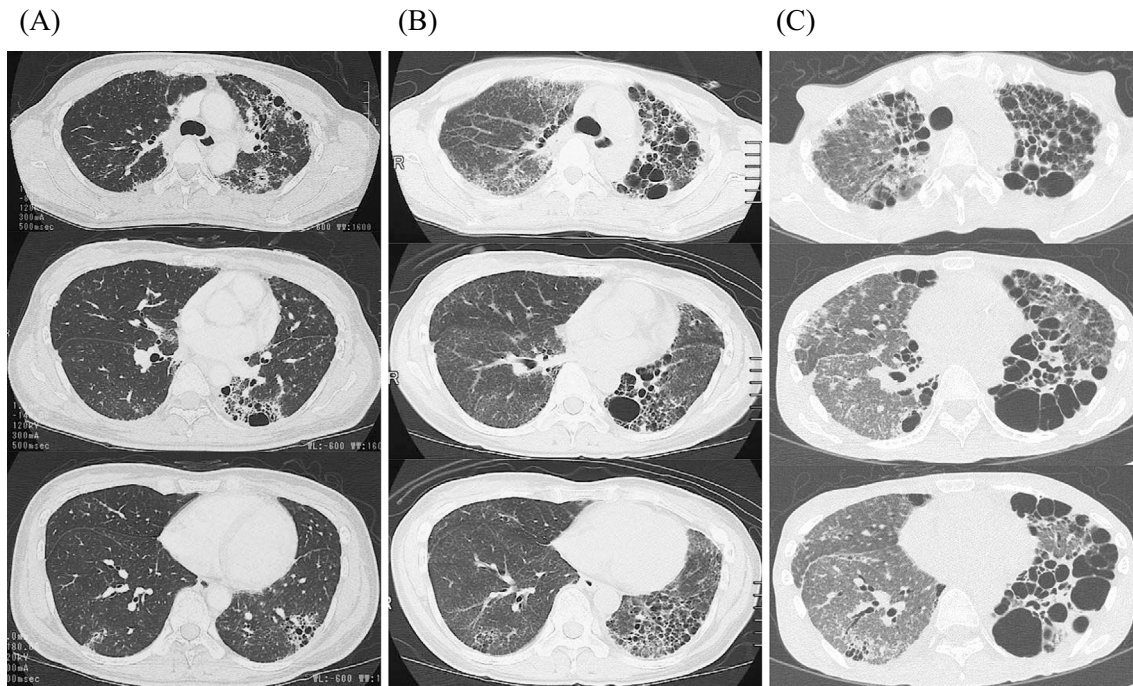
High-resolution computed tomography. (A) At the first hospital visit (four years before visiting our hospital). (B) At the beginning of pirfenidone therapy (six months before visiting our hospital). (C) At the last admission (nine months after visiting our hospital).
